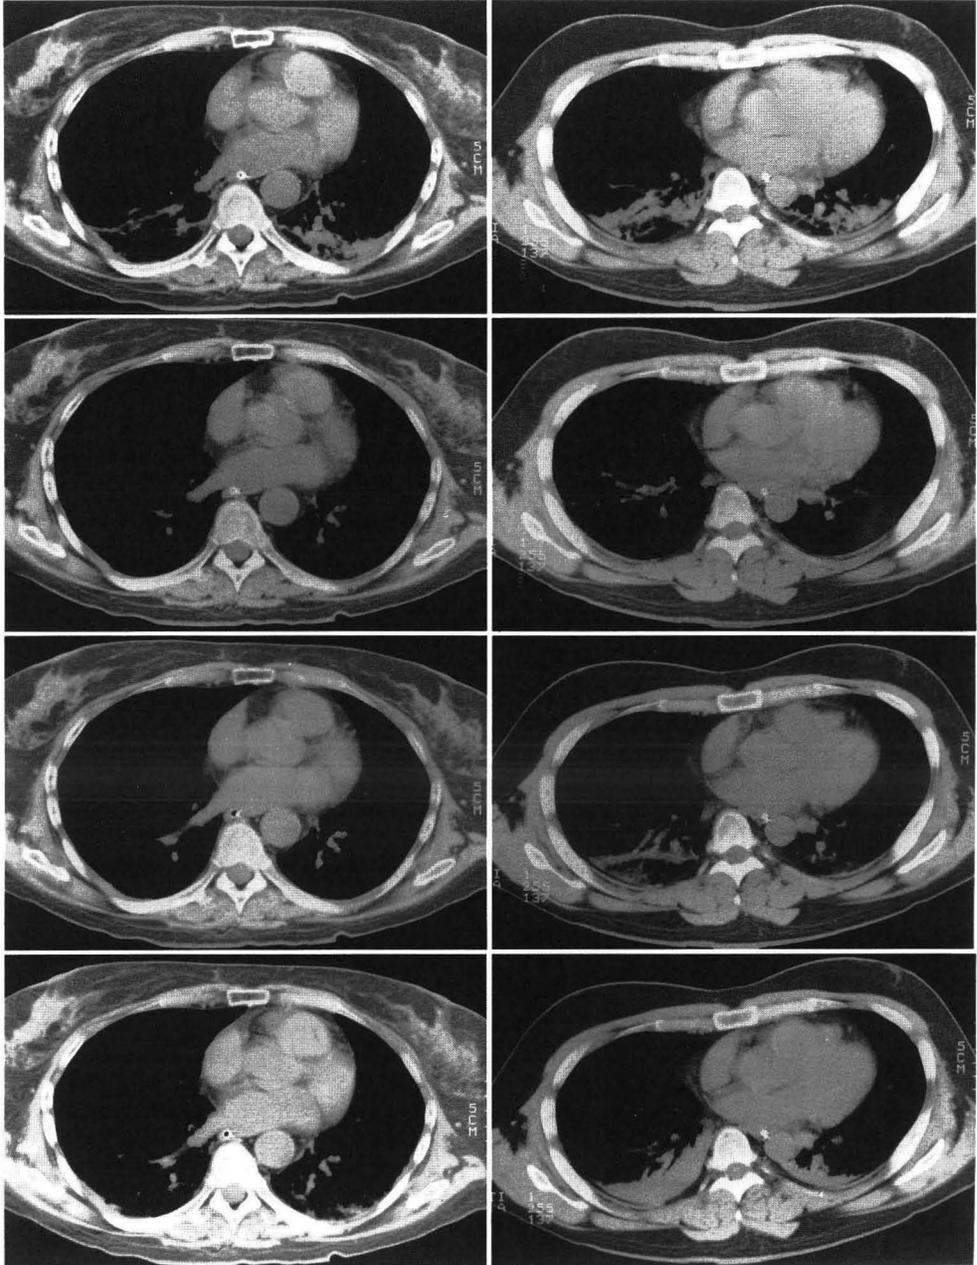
Computed tomography (CT) of the lungs in two patients. The CT was positioned in the supine patient one centimeter above the right diaphragm, and all scans were taken at end-expiration.
